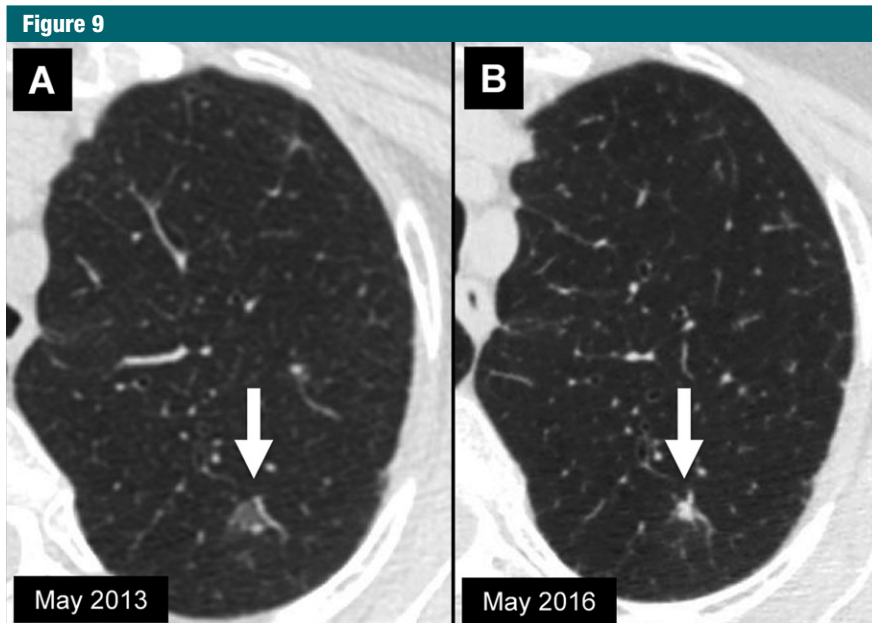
Sequential transverse CT sections of a nodule (arrow) in the left upper lobe. Although the average diameter of the nodule has decreased from, A, 13 to, B, 8 mm, solid transformation and irregular margins make it suspicious. Later resection confirmed invasive adenocarcinoma.
